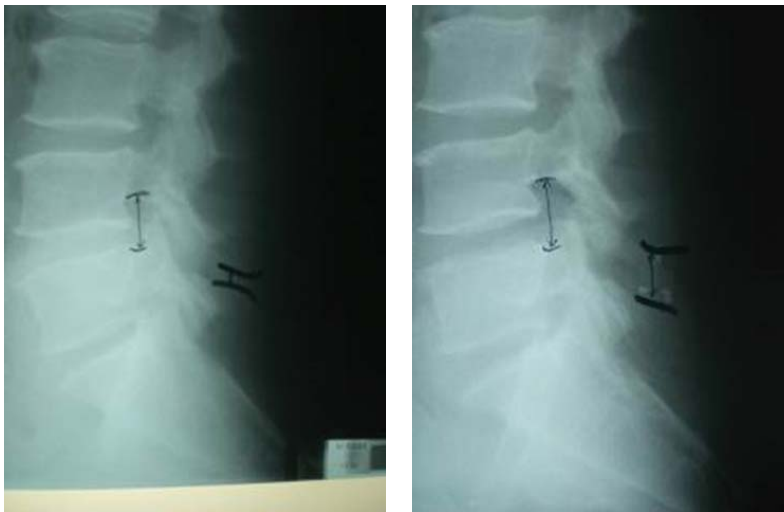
Preoperative (left) and postoperative (right) lateral roentgenograms. (Lateral roentgenograms after implantation of interspinous device shows separation of the posterior elements with accompanying unloading of the facet joints, widening the intervertebral foramen and thus decompressing the vertebral canal and relieving the load on the disc).
